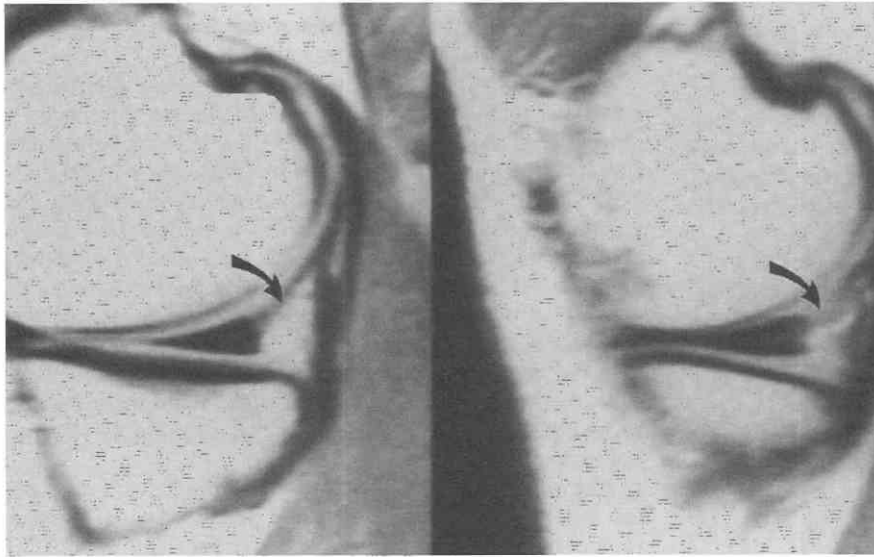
Normal peripheral third of the meniscus. Sagittal T1-weighted images reveal normal increased signal intensity at the periphery of the posterior horn of the medial meniscus where neurovascular structures and fatty tissue are present (*arrow*). This may be quite prominent, sometimes measuring 4 to 6 mm in width.
